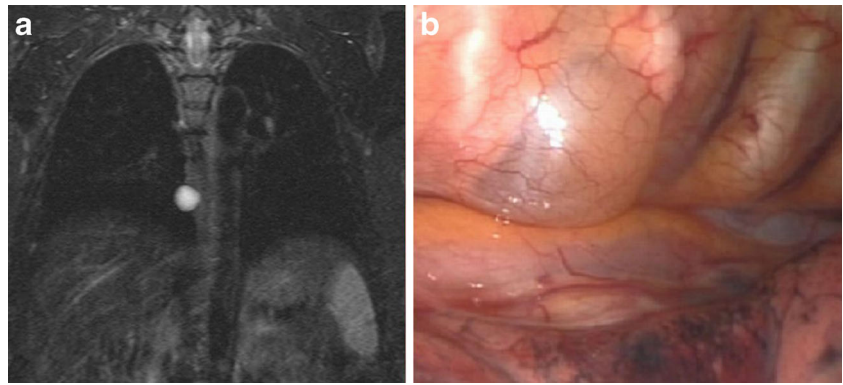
a A coronal T1-weighted MRI image showing a neurenteric cyst in the right posterior mediastinum. b Appearance of the neurenteric cyst at operation
